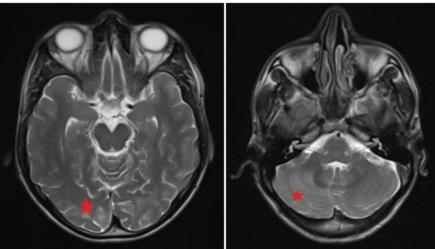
Reduced hyperintensity in the T2 Flair sequence in brain MRI compared to figure 1.
